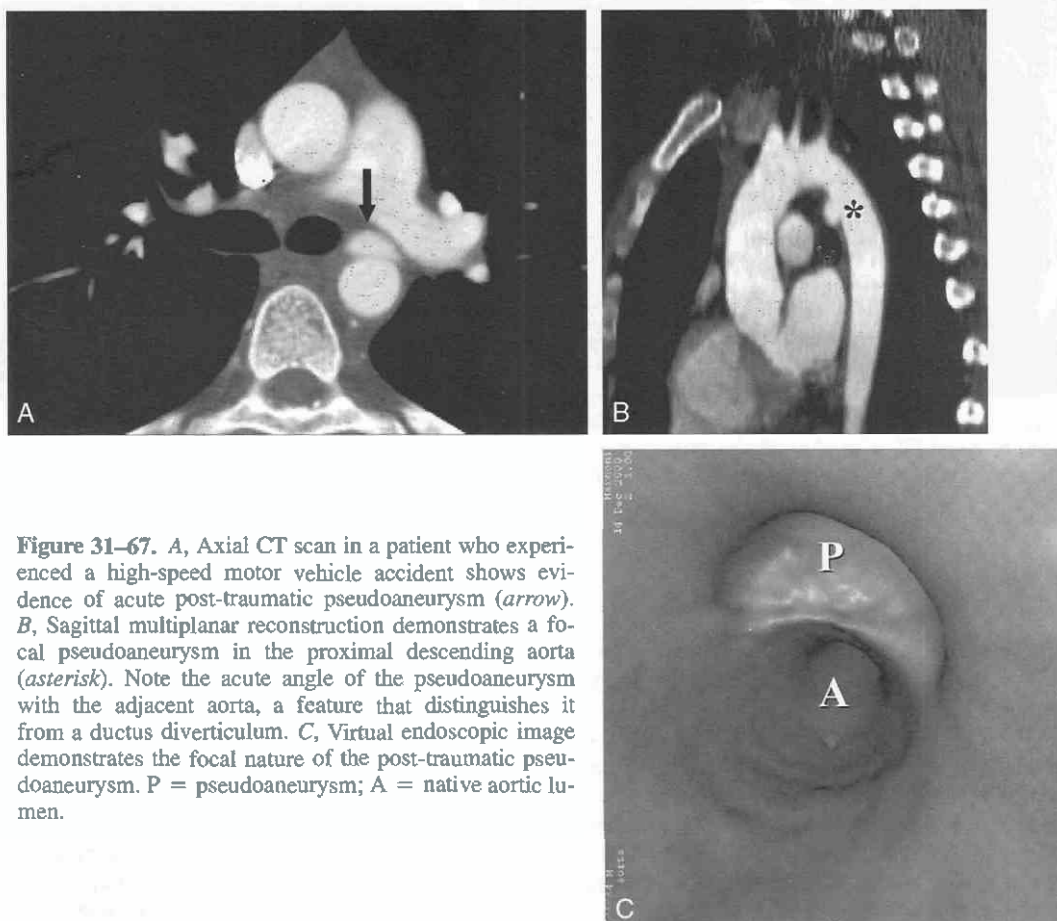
A, Axial CT scan in a patient who experienced a high-speed motor vehicle accident shows evidence of acute post-traumatic pseudoaneurysm (arrow). B, Sagittal multiplanar reconstruction demonstrates a focal pseudoaneurysm in the proximal descending aorta (asterisk). Note the acute angle of the pseudoaneurysm with the adjacent aorta, a feature that distinguishes it from a ductus diverticulum. C, Virtual endoscopic image demonstrates the focal nature of the post-traumatic pseudoaneurysm. P = pseudoaneurysm; A = native aortic lumen.
